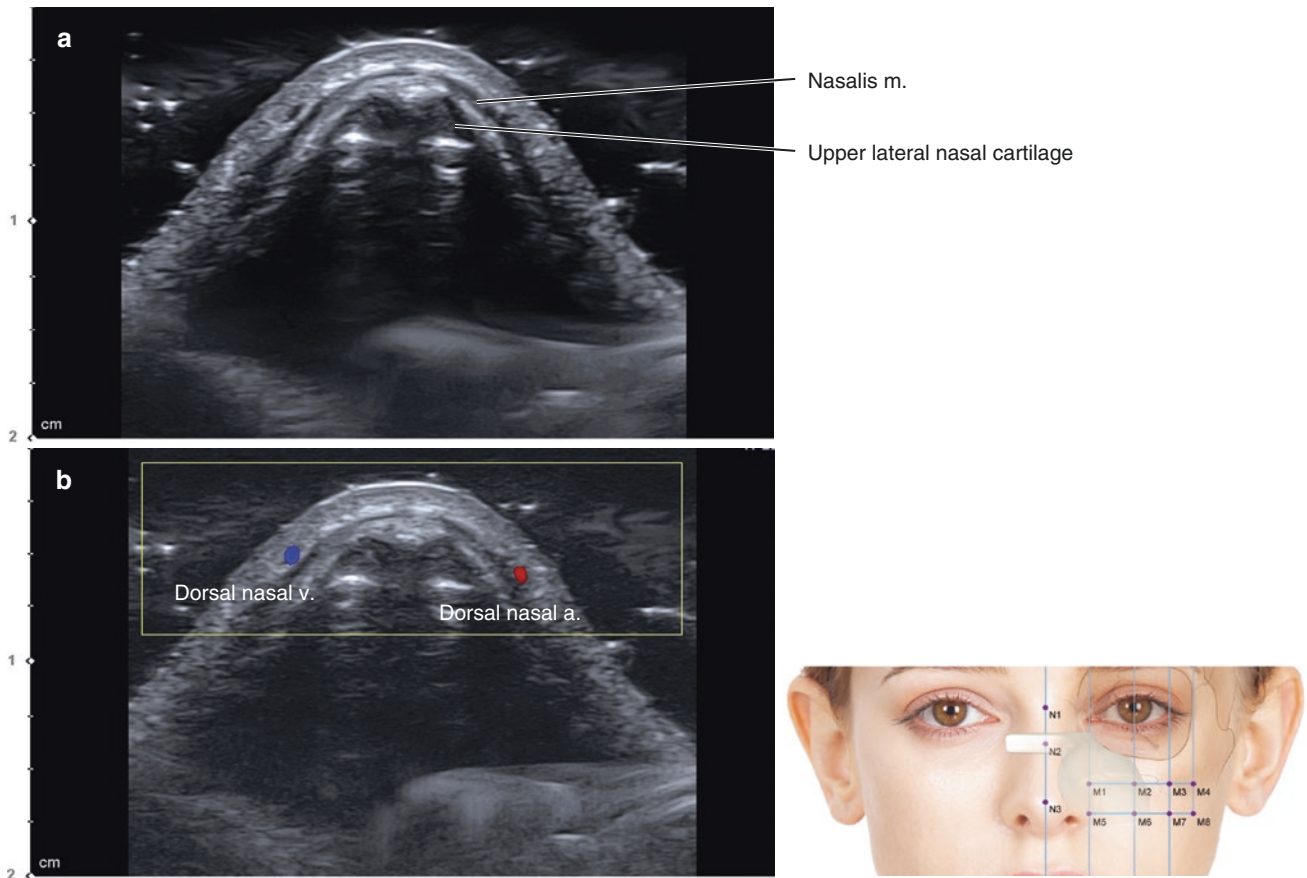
Ultrasonography of the rhinion (N2). (a) B mode (transverse view, 15 MHz by linear transducer), (b) Doppler mode (transverse view, 15 MHz by linear transducer), (c) B mode (sagittal view, 15 MHz by linear transducer), and (d) Doppler mode (sagittal view, 15 MHz by linear transducer). (Published with kind permission of © Hee-Jin Kim 2020. All Rights Reserved)
